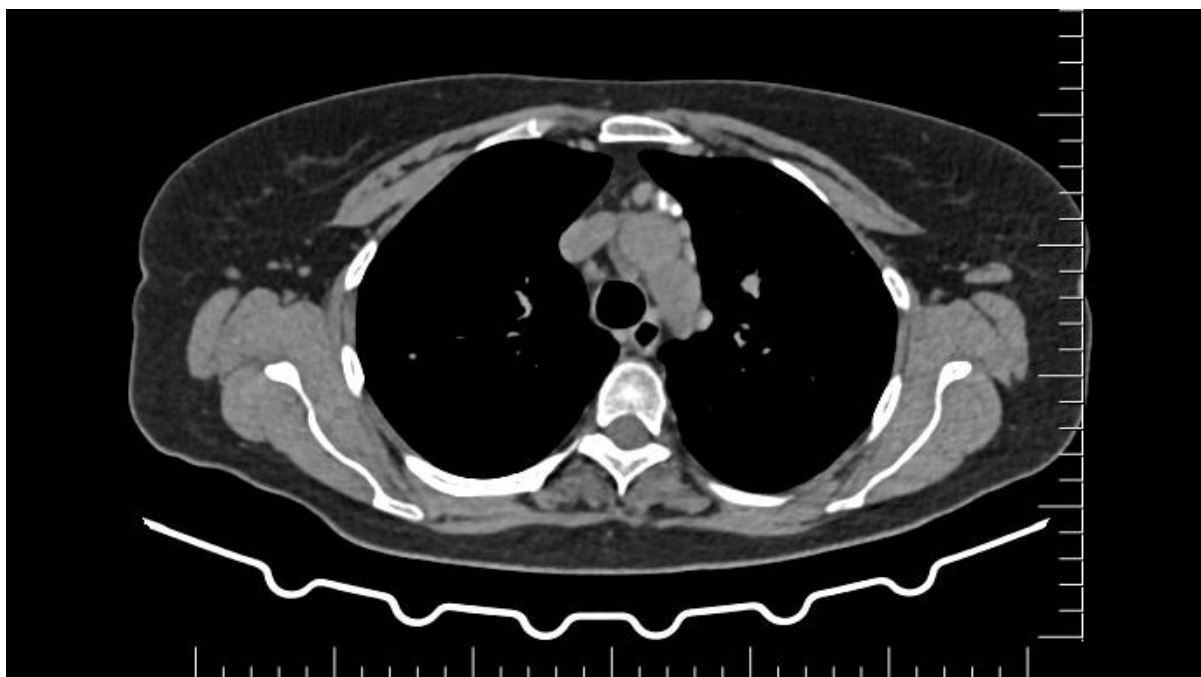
CT scan chest plain images showing calcified nodes in left prevascular region
